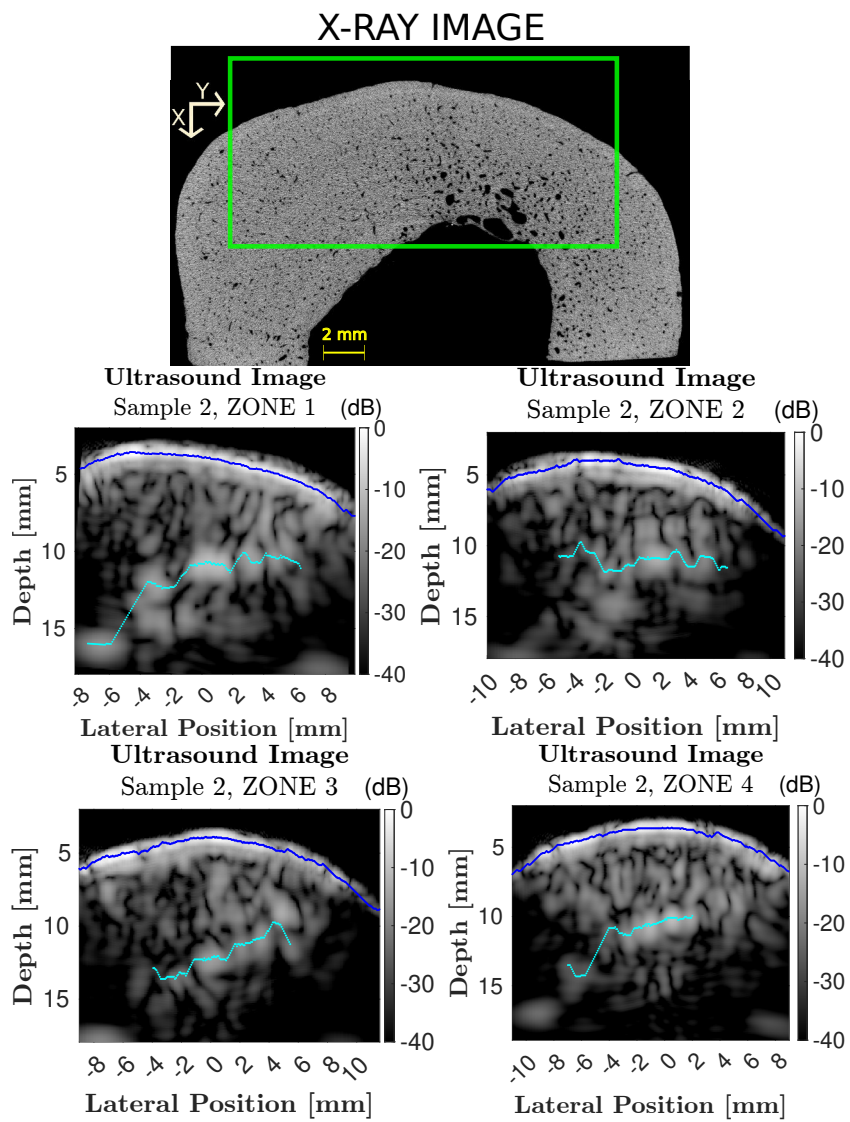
Ultrasound images of each measurement zone of Sample 2.
